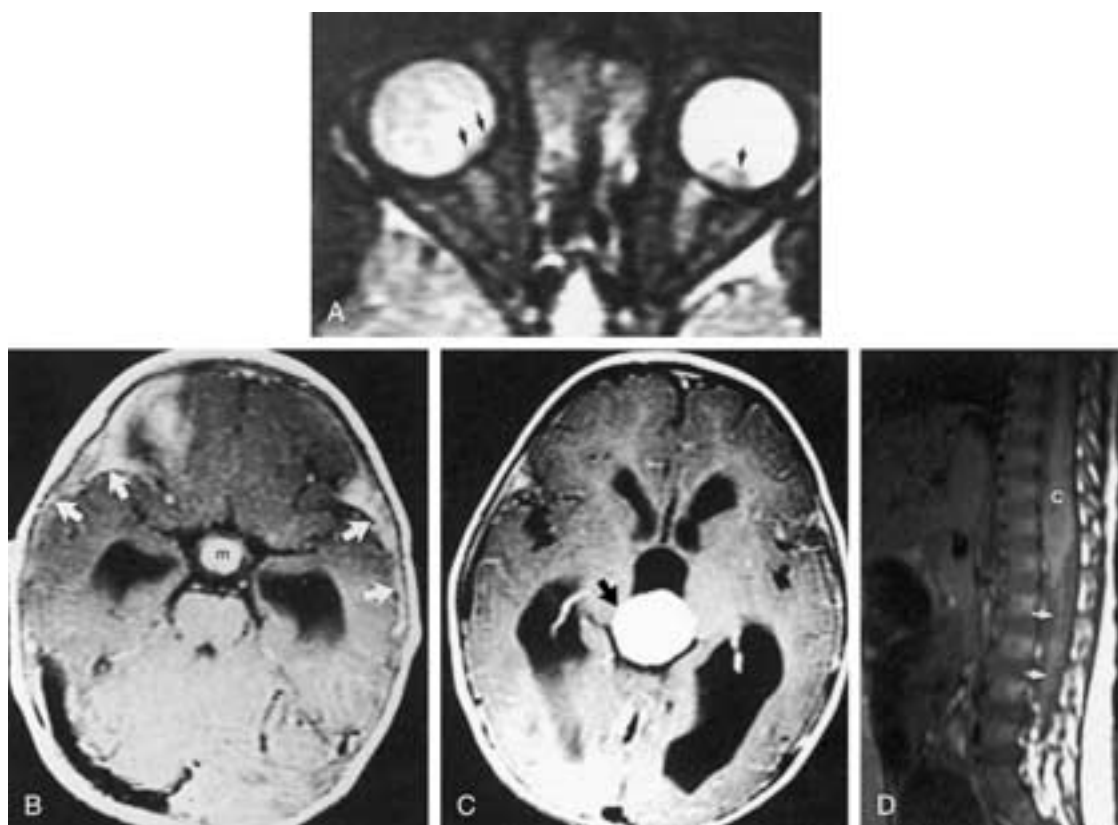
Tetralateral retinoblastoma. A, Axial T2-weighted MR image shows bilateral retinoblastoma (arrows). B, Enhanced axial T1-weighted MR image shows a markedly enhancing suprasellar mass (*m*). Note the subarachnoid spread of the tumor, seen as leptomeningeal enhancement along the sylvian fissures (arrows). C, Enhanced axial T1-weighted MR image shows marked enhancement of a pinealoblastoma (arrow). D, Enhanced sagittal T1-weighted MR image obtained a few months later shows diffuse distal spinal cord (*C*) and subarachnoid metastases (arrows).
